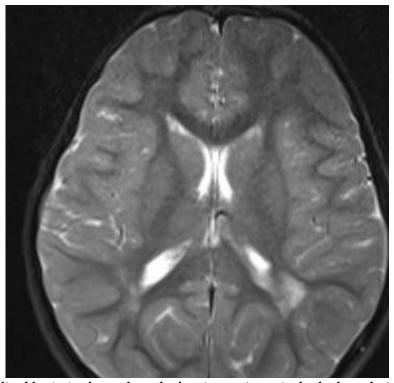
MRI visualized brain in the neck study showing periventricular leukomalacia (sequelae of old hypoxia).
